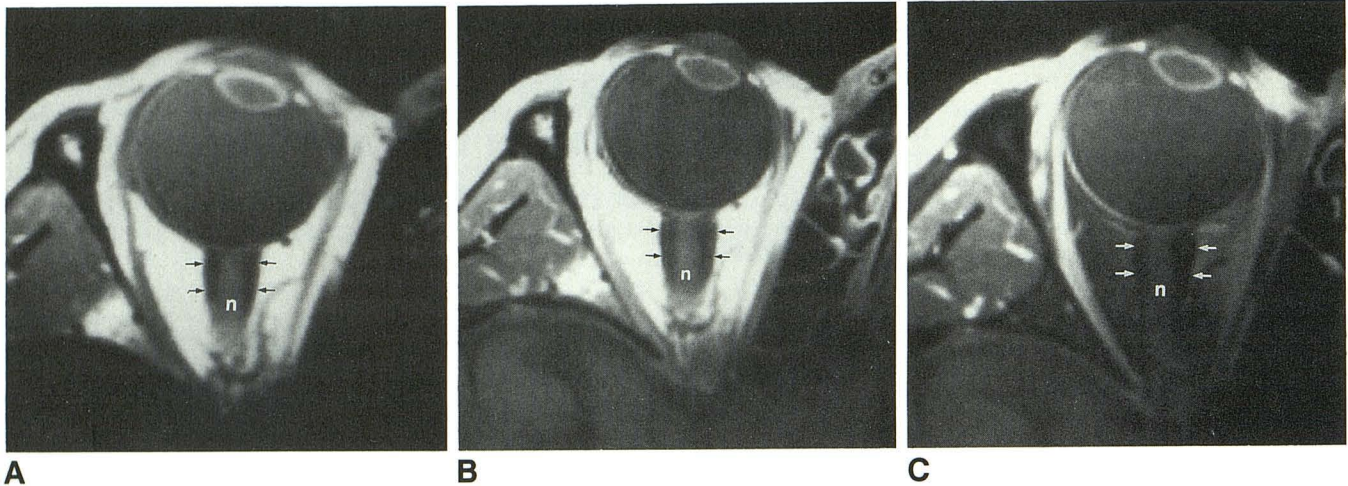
A–C, Axial T1-weighted spin-echo MR images of a normal orbit before IV injection of gadopentetate dimeglumine (A), after contrast injection (B), and with suppression after contrast injection (C). Fat suppression results in the low signal intensity of the intraconal fat in C. There is no appreciable enhancement of the optic nerve (n) or sheath (arrows) in B or C. Enhancement of the extraocular muscles, seen in the postcontrast images, is more apparent with the fat-suppression technique (C). This individual has a relatively prominent nerve sheath. The relatively increased brightness of soft tissue anterolaterally is a reflection of greater sensitivity of the reception field near the surface coil.
